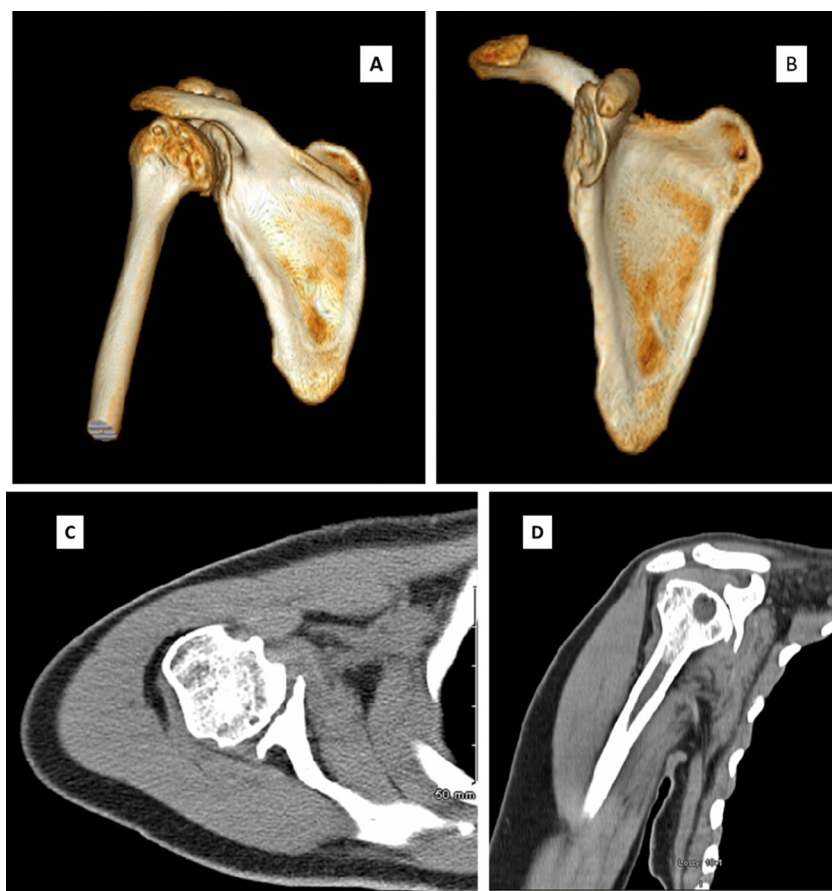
Presurgery 3-dimensional (3D) reconstructions demonstrate (A) significant degenerative changes at the proximal humerus and glenoid process and (B) show the glenoid process with severe glenoid wear. A presurgery computed tomography scan (C) axillary view demonstrates bony erosion, increased retroversion, and small glenoid process size, and a (D) coronal view demonstrates bony erosion, increased retroversion, and small glenoid process size.
